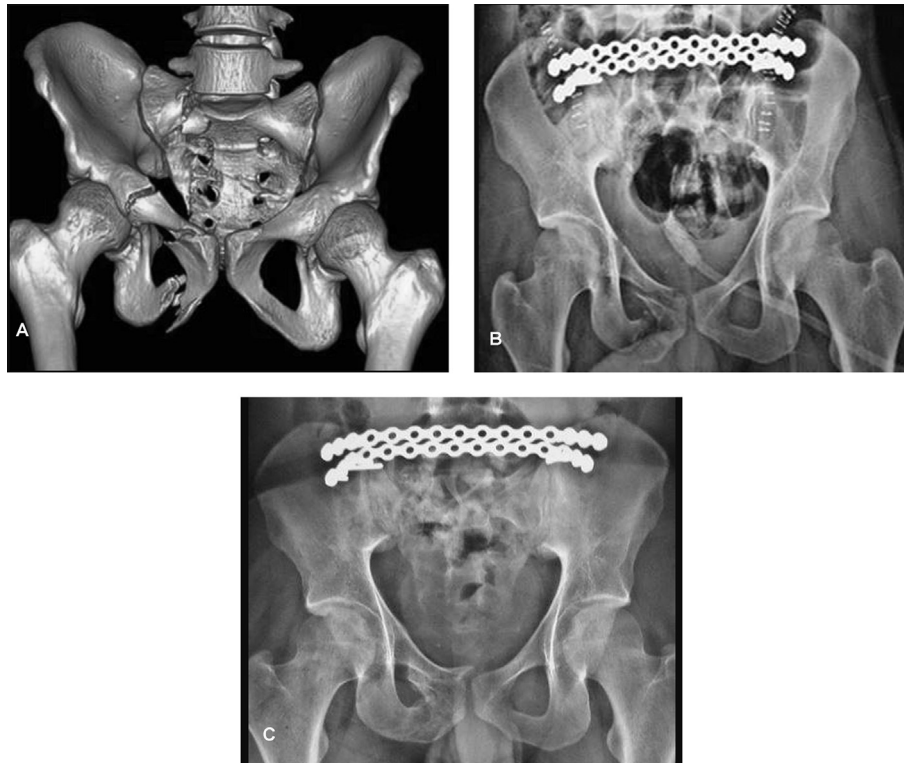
Management of an unstable pelvis fracture Tile C with associated anterior Morel-lavallee lesion and extra peritoneal bladder rupture in a 42-year male. (A) 3D reconstruction film of pelvis showing comminuted and displaced pubic rami fractures (Right) and ipsilateral zone 2 sacral fracture with comminution. (B) Post operative radiograph shows a stable posterior construct using two percutaneous trans-iliac plates with alignment of anterior ring. (C) At 18 months follow up- sacrum united (Lindhal's grade A). Although, minimal loss of 8 mm was noted, the pubic rami united well without any implant failures.
